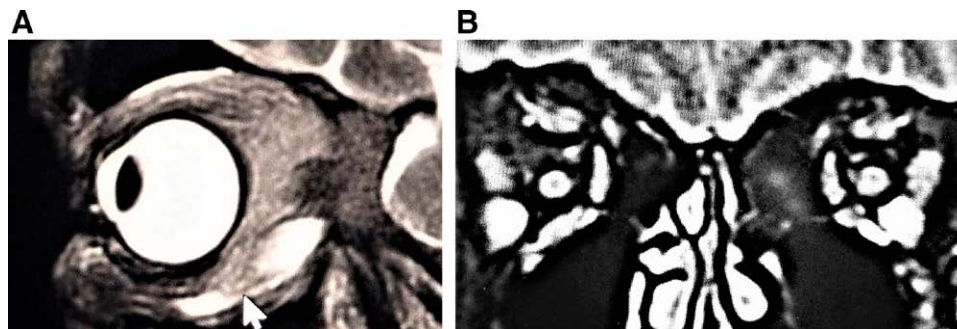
MRI of the orbits at 3 months. A, Radiesse appears as a white stripe lateral and below the right bulbus (arrow). B, Bellafill and Radiesse are recognizable as round white bulks lateral and behind the bulbus.
